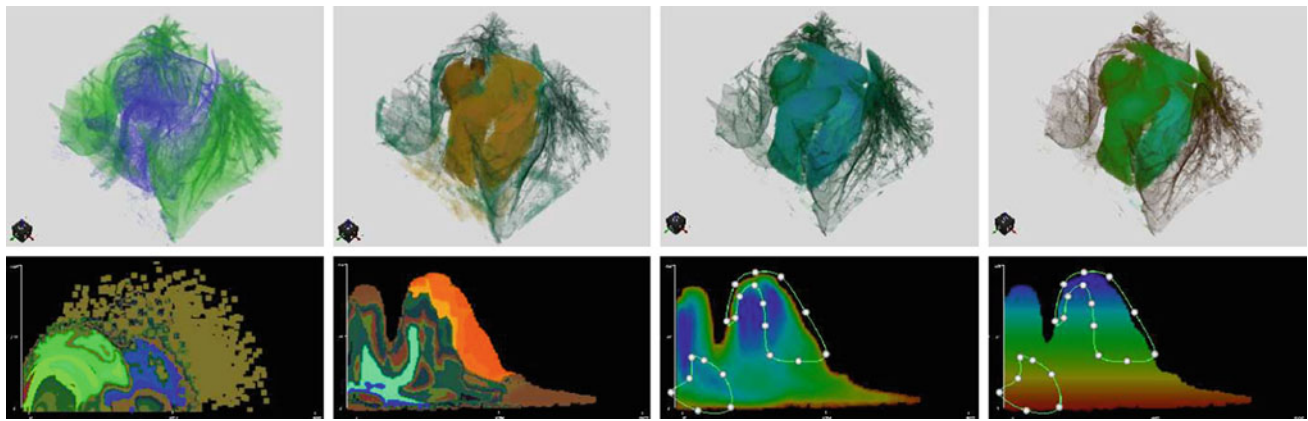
A thoracic CT containing the lungs and the heart. A selective rendering of these structures is shown. The *left* images show the visualization based on the IGM histogram where the typical appearance of such renderings with strongly emphasized, opaque boundaries can be perceived. The three *right* images show SSE histogram-based
